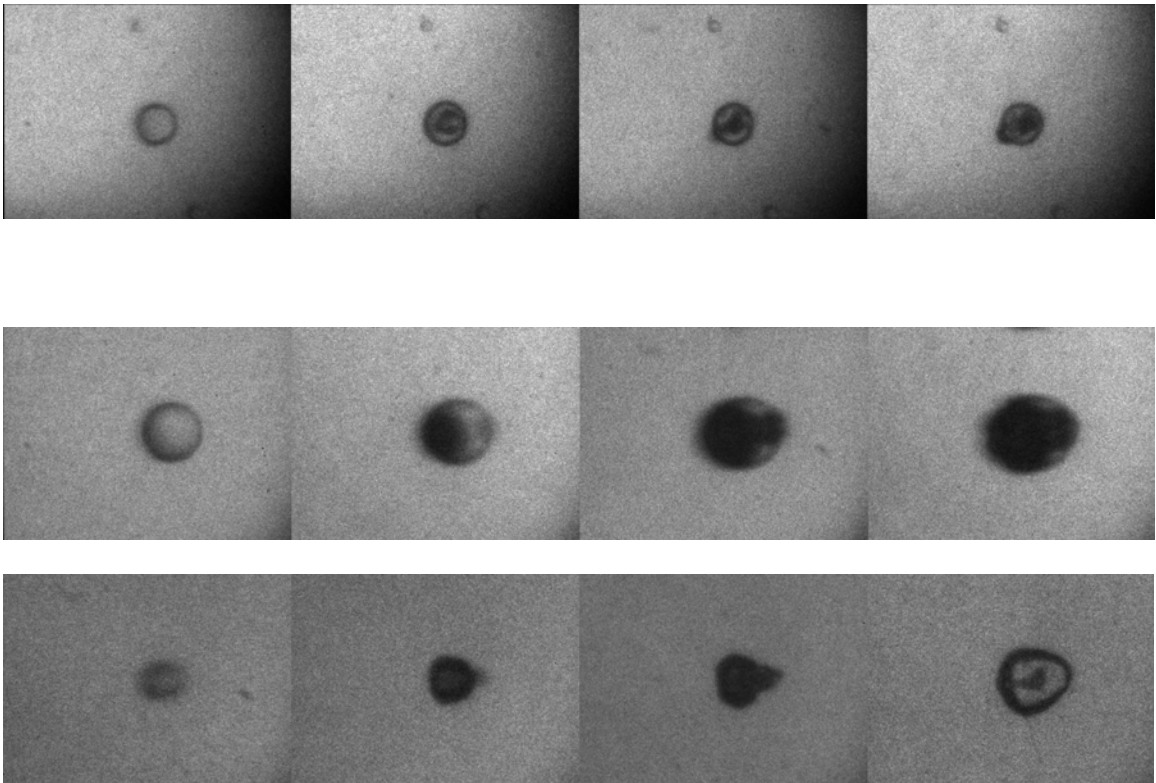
Initiation of ADV by ultrasound for three different droplets. Nucleation sites were observed in the interior of the droplet, albeit the limited resolution of details. Initial droplet diameter was 27 microns (first row), 40 microns (second row) and 23 microns (third row) respectively; frame-by-frame timelines for all 3 image sets were 0, 0.5, 1, 1.5 microseconds.
